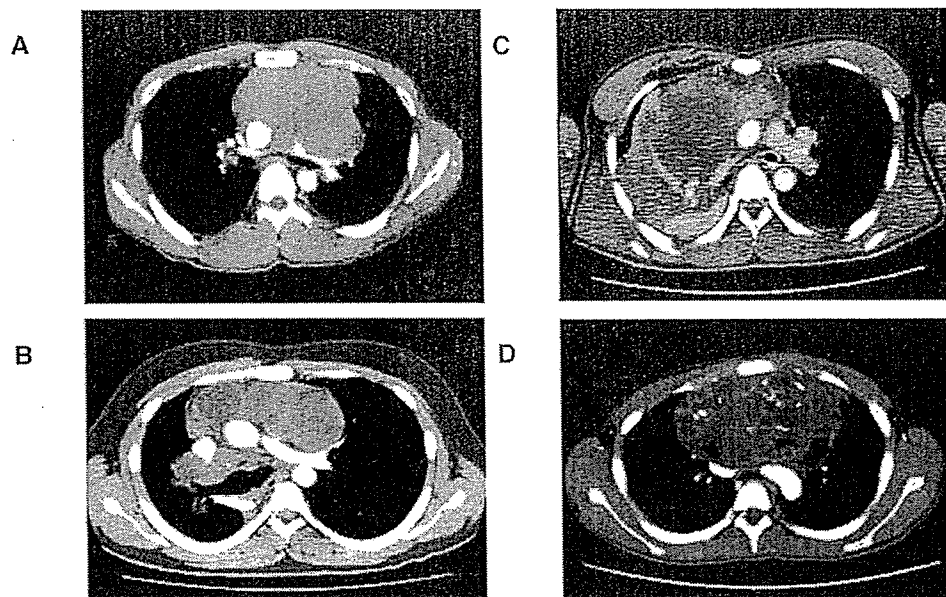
A, Patient 1: the right main PA and left main bronchus are seen compressed by an anterior mediastinal tumor. B, Patient 2: a metastatic tumor surrounding the great vessels is shown causing bronchial stenosis. C, Patient 3: emergency CT image taken after a needle biopsy revealing an intratumorous hemorrhage causing ventilation insufficiency. D, Patient 4: an anterior huge mass is seen compressing the left main bronchus and right main PA. The content was heterogeneous and consisted of cystic and calcified portions.
